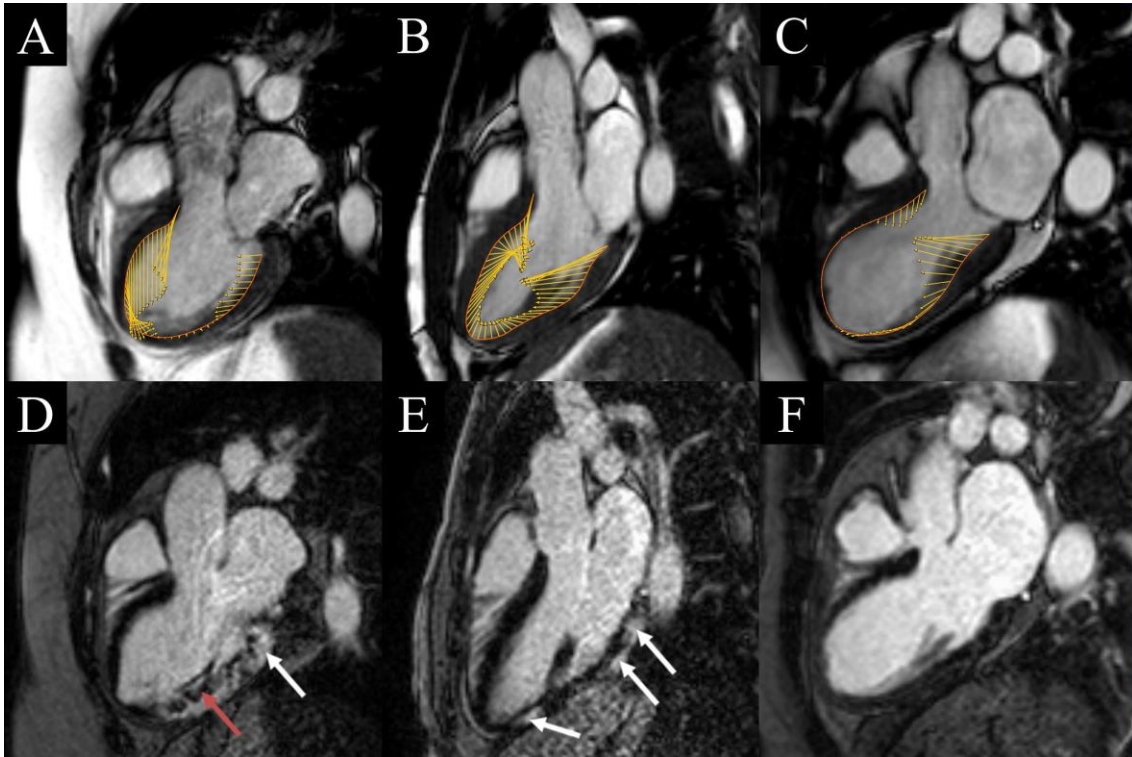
Cardiac magnetic resonance images of patients with myocardial infarction (A and D), myocarditis (B and E) and Takotsubo syndrome (C and F) from Vago et al. (2). Cine movie images depict endocardial segmentation and contraction pattern during strain analysis (A–C). Late gadolinium-enhanced images show transmural necrosis (white arrow) and microvascular obstruction (red arrow) in patients with acute infarction (D); patchy, midmyocardial necrosis in myocarditis (white arrows) (E); and the lack of LGE in Takotsubo syndrome (F). Abbreviations: LGE = late gadolinium enhancement.
